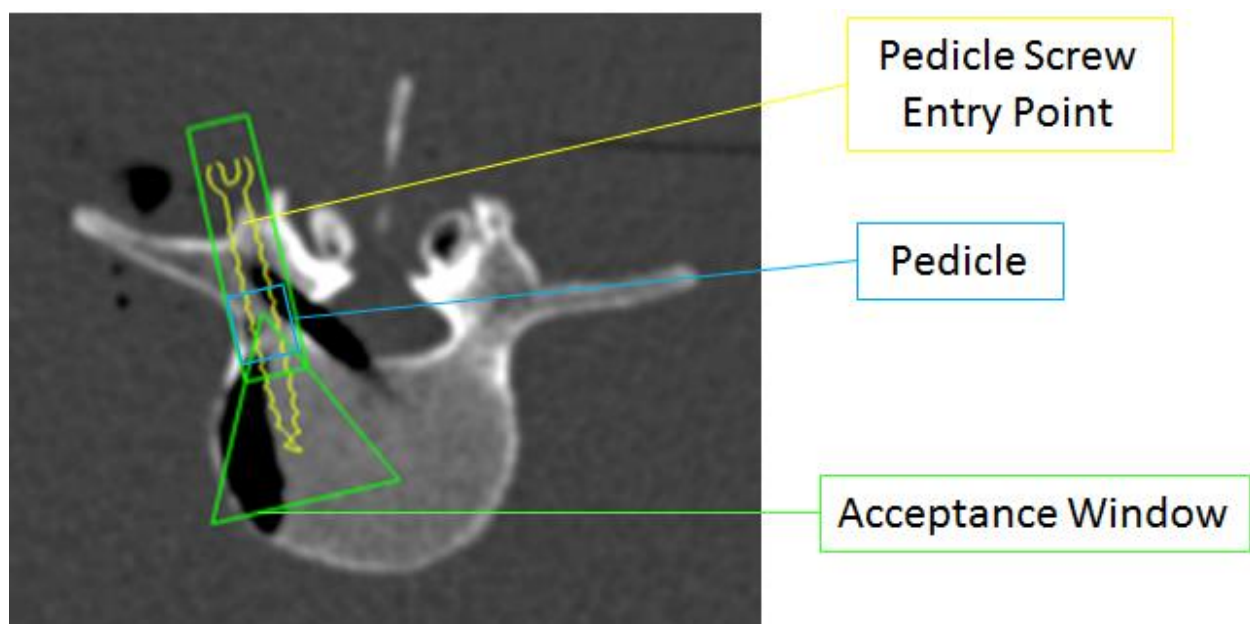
An axial CT slice of a vertebrae with a model pedicle screw secured in place
